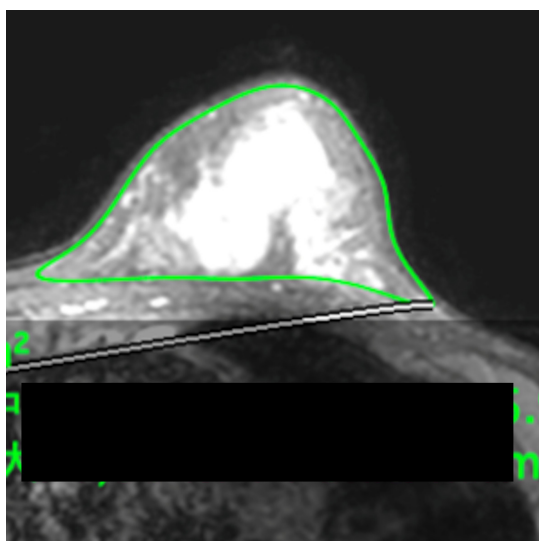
Measurement of breast volume using MRI. The margins of the sectioned breast images were traced in each slice (Figure 3). The measurement method using MRI is the same as that for CT. The MRI image is displayed upside down
